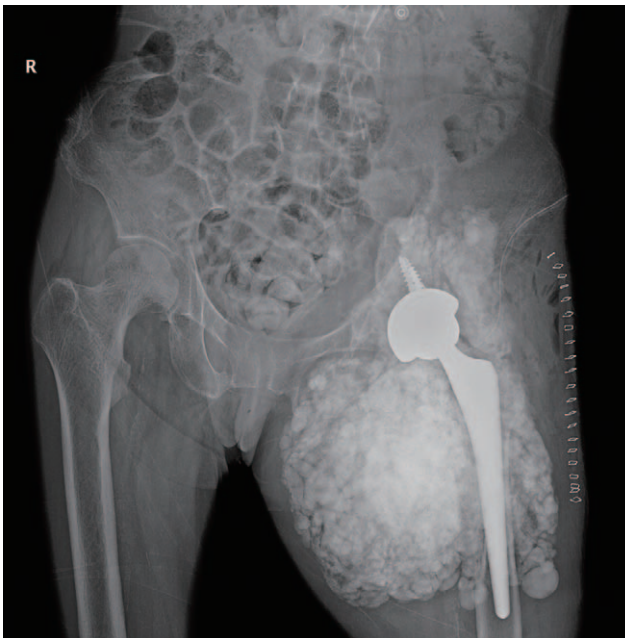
Postoperative plain radiographs after left total hip arthroplasty.
